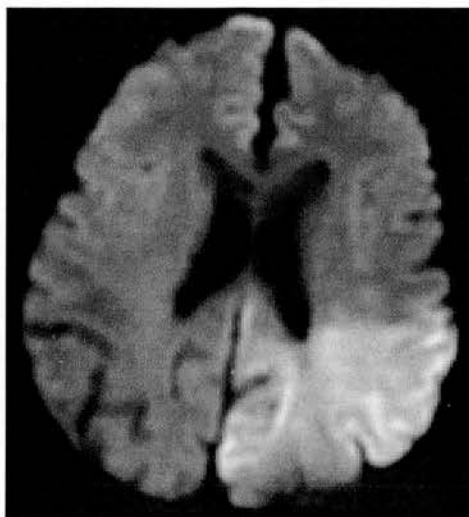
DWI from a patient with a left hemisphere ischaemic lesion at 4 hours after stroke onset. Note that the DWI lesion is not uniformly hyperintense, with areas of ill-defined, subtle hyperintensity.
